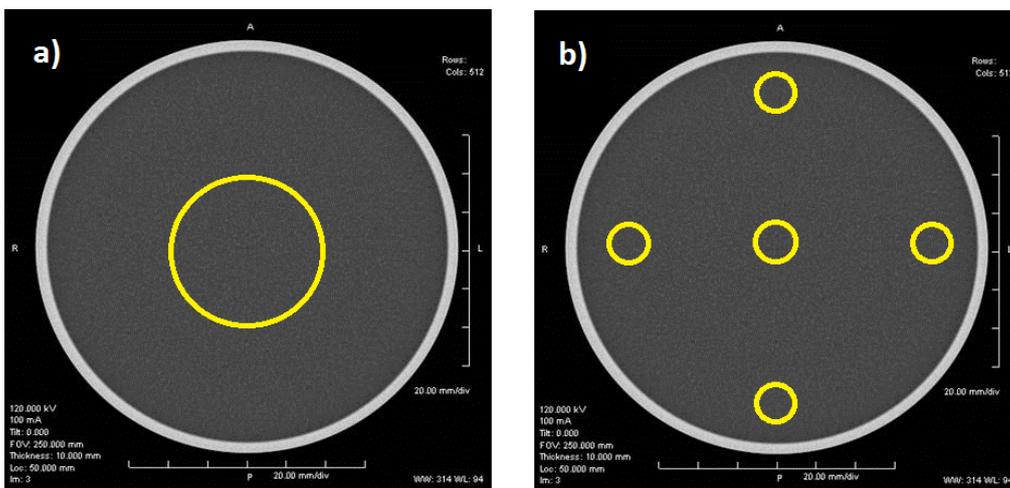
Example of proper ROI placement for analysis of a) CT number and image noise, and b) image uniformity.
